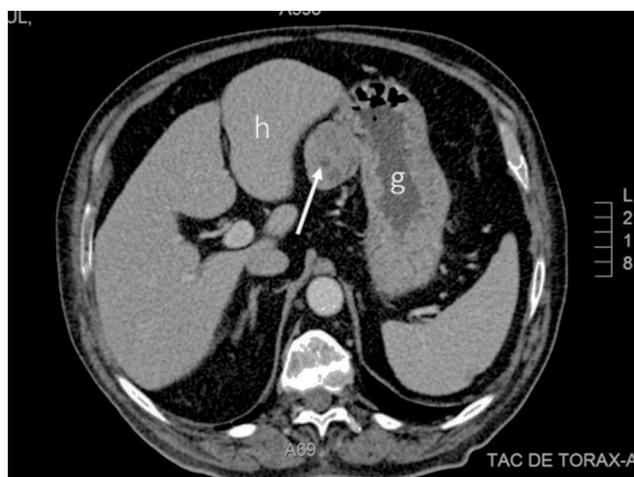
Abdominal CT. Axial section at the level of the upper portion of the abdomen in which a 4cm solid lesion (arrow) located between the liver (h) and stomach (g) can be observed.
